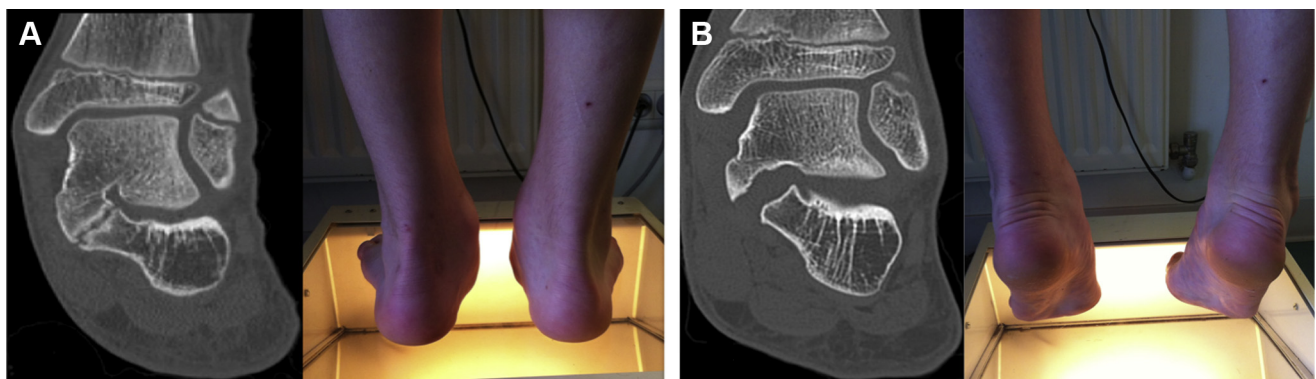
(A) A 13-year-old boy presented with a right rigid flatfoot and talocalcaneal coalition, as shown on computed tomography. (B) One year after arthroscopic talocalcaneal coalition resection, he showed no recurrence of the coalition and showed normal subtalar joint motion.
